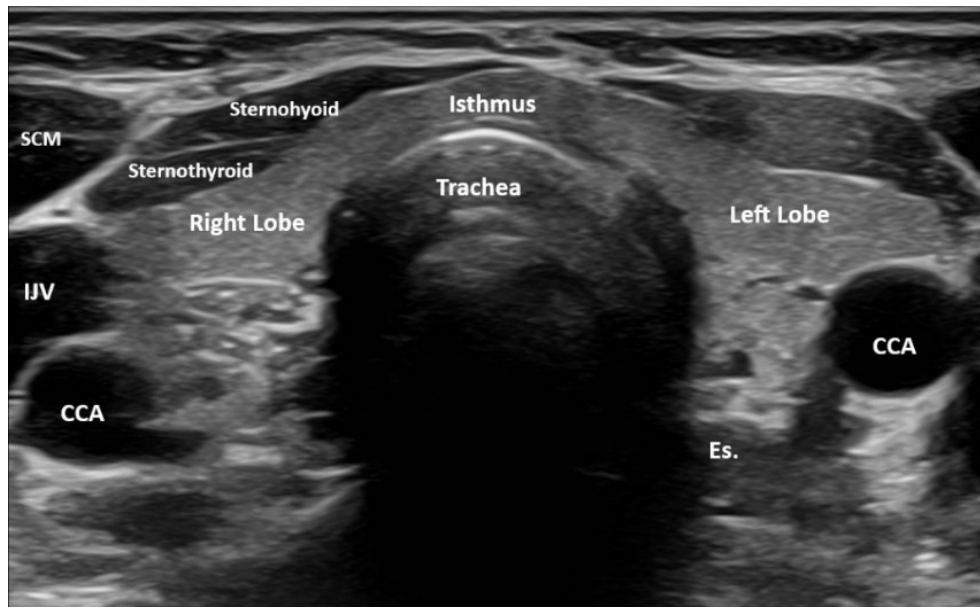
Normal Thyroid Ultrasonography – transverse scan. CCA = Common carotid artery; IJV = internal jugular vein; SCM = sternocleidomastoid muscle; Es.= esophagus.
